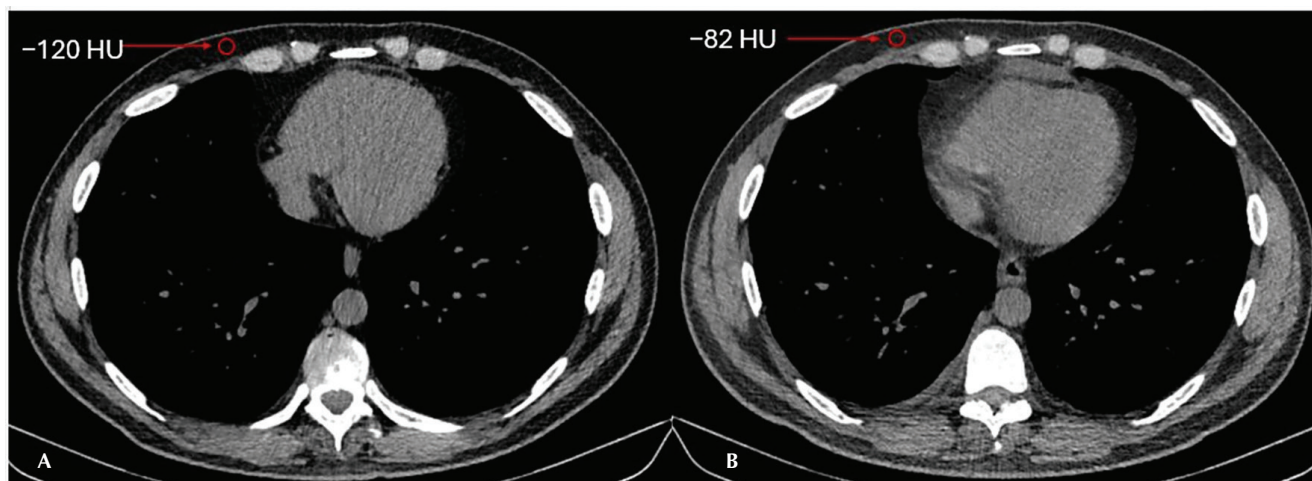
Representative axial non-contrast chest CT images demonstrating subcutaneous adipose tissue attenuation measurements before (A) and after (B) allogeneic hematopoietic stem cell transplantation. A circular region of interest (ROI) was placed within the anterior chest wall subcutaneous adipose tissue at the level of the xiphoid tip while avoiding skin, muscle, vessels, fibrous septa, and imaging artifacts. The displayed attenuation values represent the mean ROI attenuation (HU)
